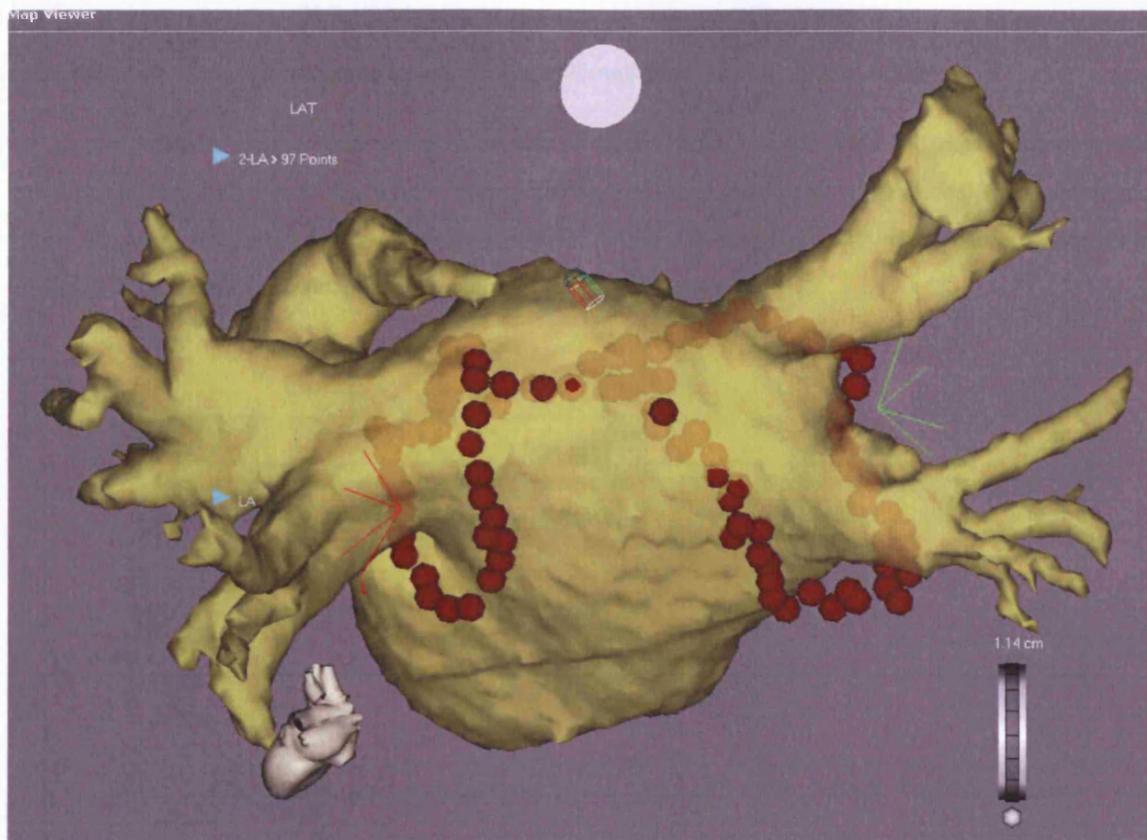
64 slice CT registered to an electroanatomic map (CARTO). A lesion arrangement is shown with ablation lines circling the right and left pulmonary veins separately. A roof line joins both circles. The shaded area within the circles represents low voltage tissue on completion of the ablation lines.
